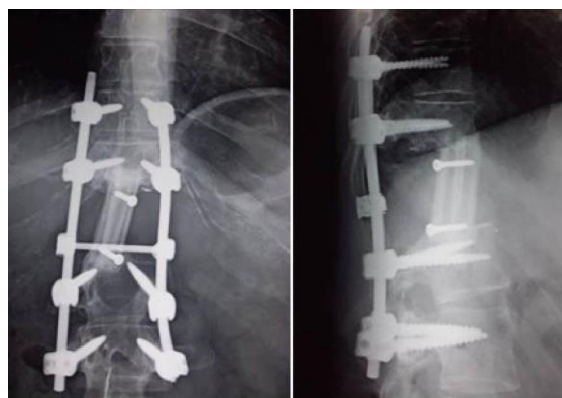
Reconstruction of the anterior column by interbodyfree non-vascularized fibular bone grafting stabilized by the posterior instrumentation: X-ray at 3 years follow-up showing consolidation without kyphosis.
